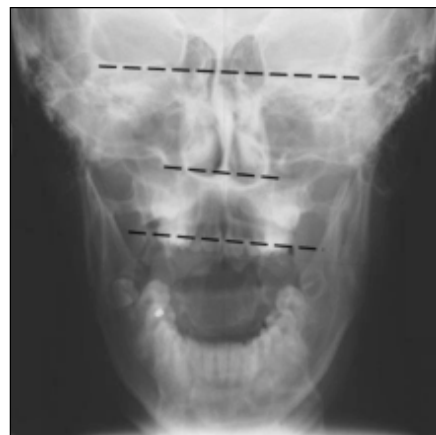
Anteroposterior Skull Radiograph of Right Torsion patient C.G.
